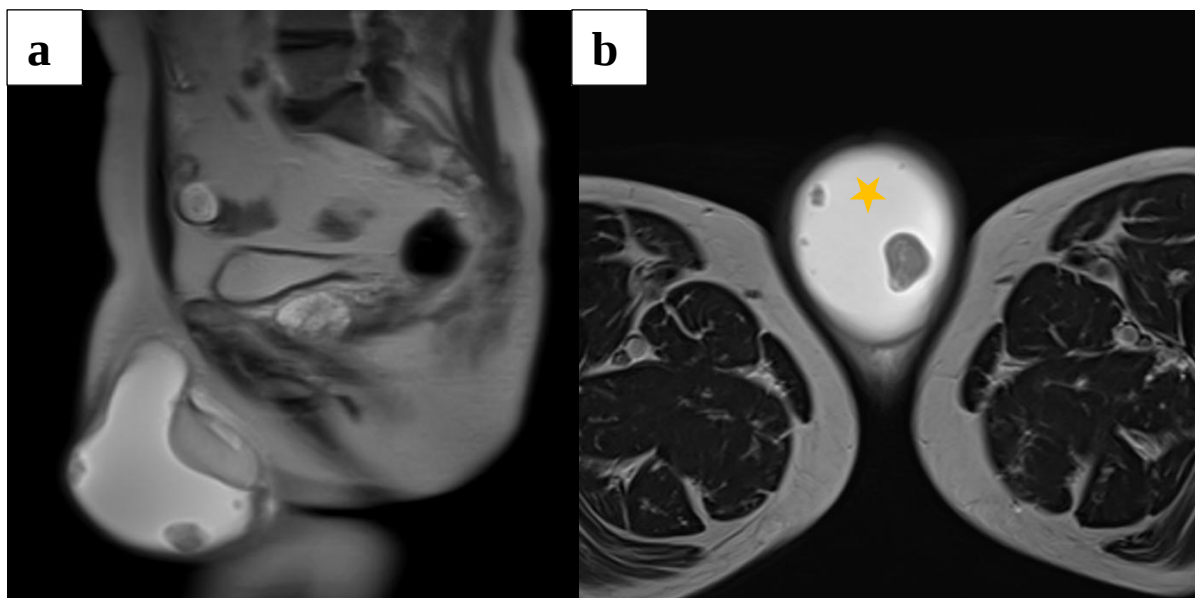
MR images of an encysted hydrocele (star) with peripheral nodular opacities attached to the wall.
